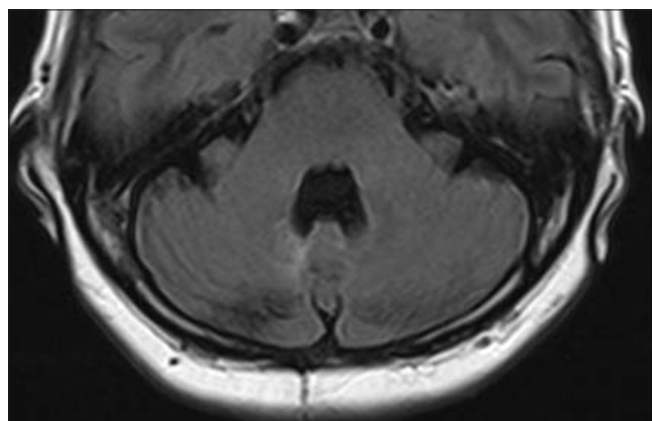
Brain magnetic resonance imaging performed 1 year after the surgery shows disappearance of the inflammatory tissue and purulent collection
